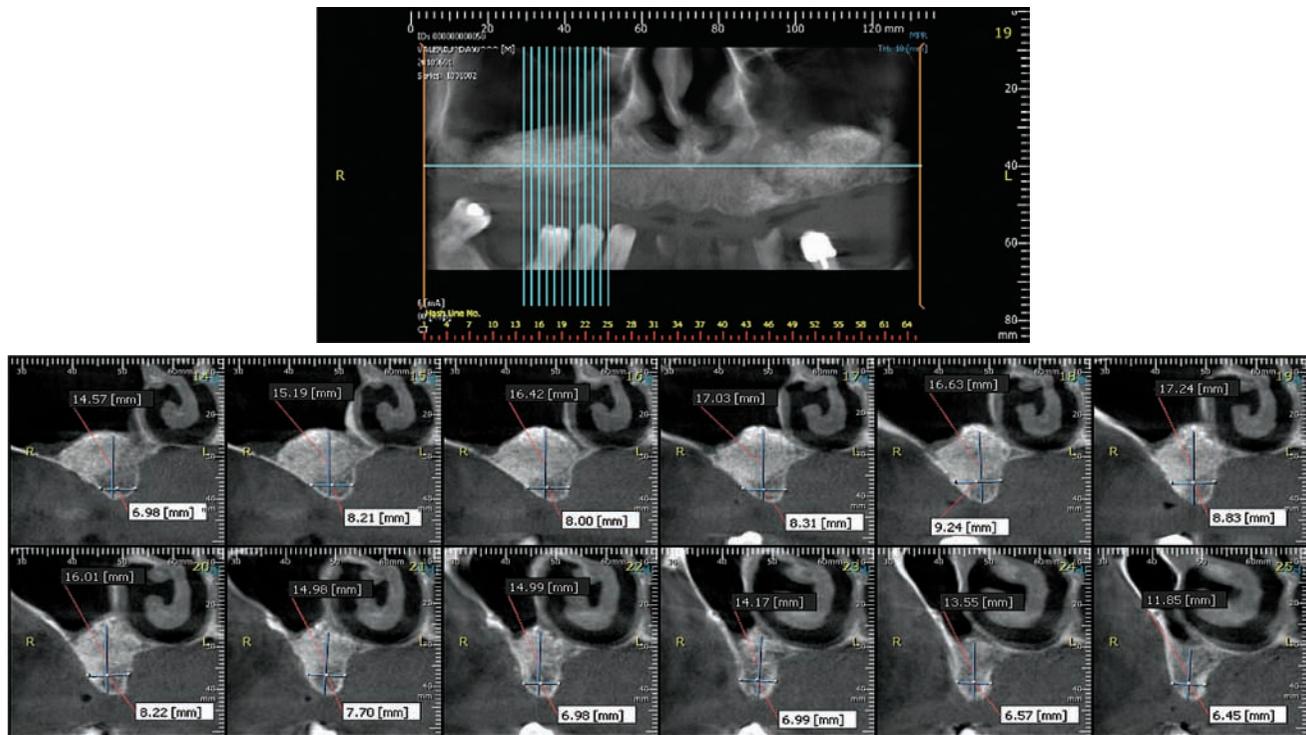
CT 10 months after maxillary sinus lift.
